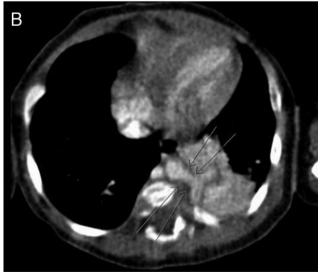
A) Computed tomography-pulmonary angiogram showing the feeding artery emanating from the aorta and supplying blood to the sequestration B) Computed tomography-pulmonary angiogram showing the feeding artery emanating from the aorta and supplying blood to the sequestration
